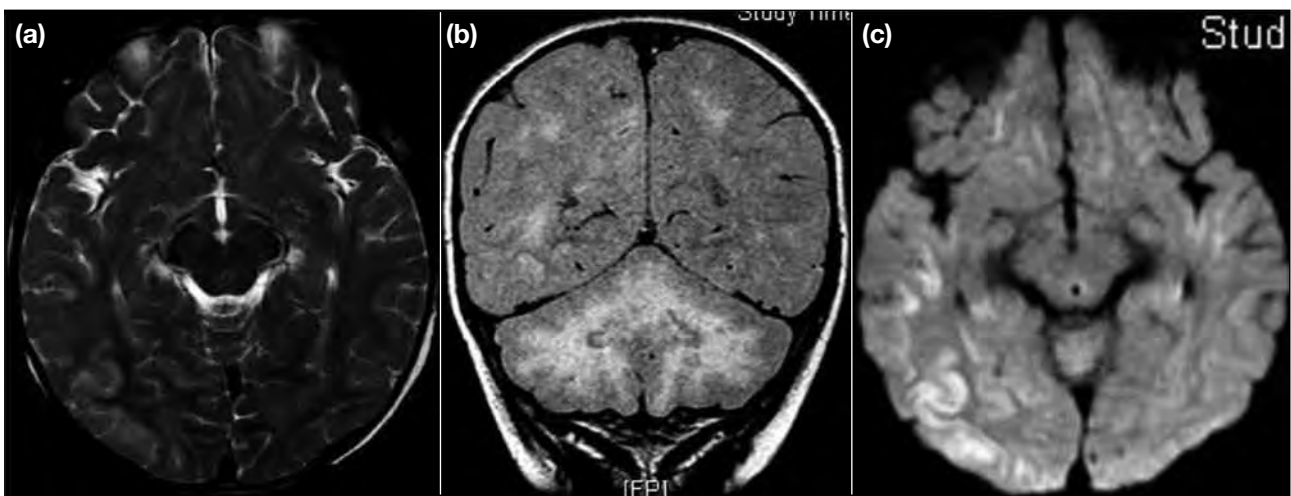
Patient 3. Magnetic resonance imaging scans showing (a) T2 and (b) fluid-attenuated inversion recovery high-intensity signals along the gyri and subcortical white matter of bilateral cerebrum and cerebellum; and (c) restricted diffusion along gyri and subcortical white matter of bilateral cerebrum and deep grey matter.
